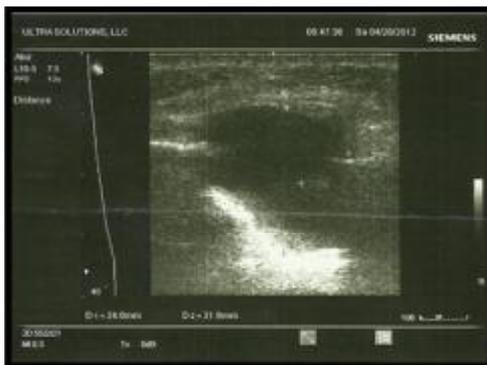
Ultrasound of periapical cyst show hypoechoic texture, well defined margin and reinforced bone
